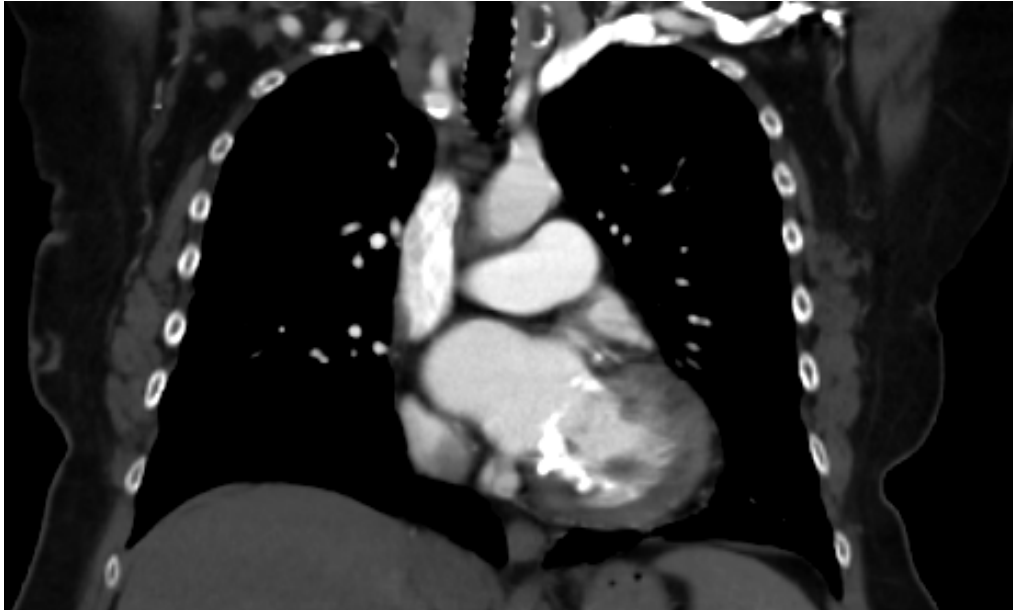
Visualization of MAC on preoperative CT
